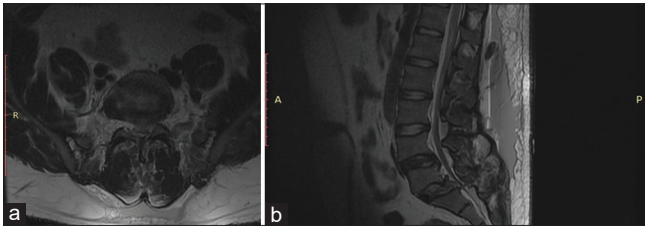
(a) Magnetic resonance imaging (MRI) T2 – Axial cut at L5/S1 level. (b) MRI T2 – Sagittal cut.
